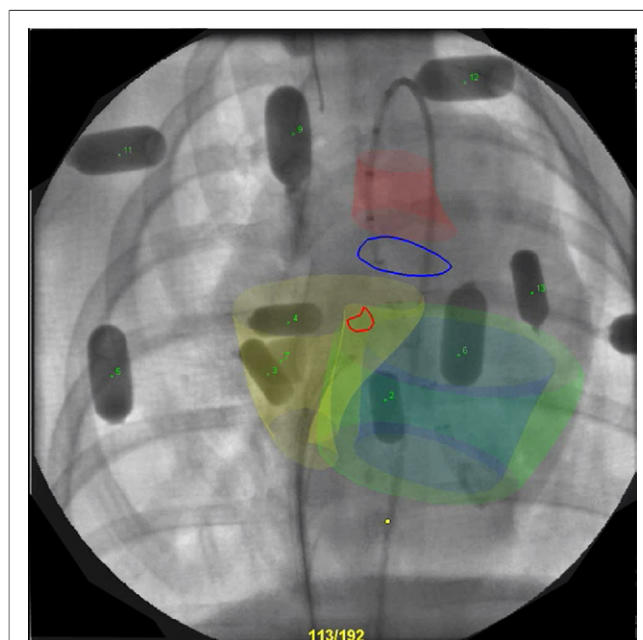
X-Ray Fused With MRI
